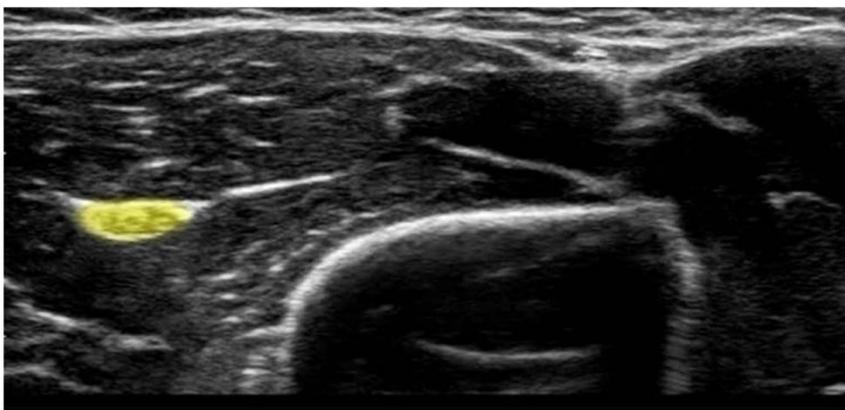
Ultrasound-guided block of the radial nerve (highlighted in yellow at the top left), 5 ml.
